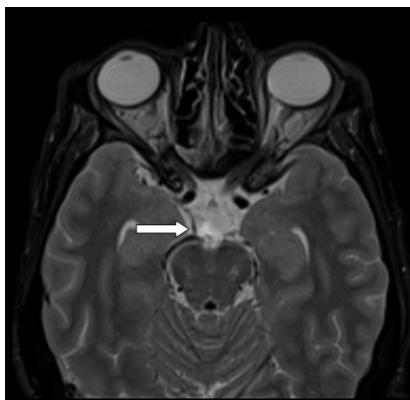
Brain MRI, orbital T2-weighted fat-suppressed sequence (slice thickness: 2.2 mm): hyperintense signal in the midline perimesencephalic region consistent with PMSH (white arrow).
